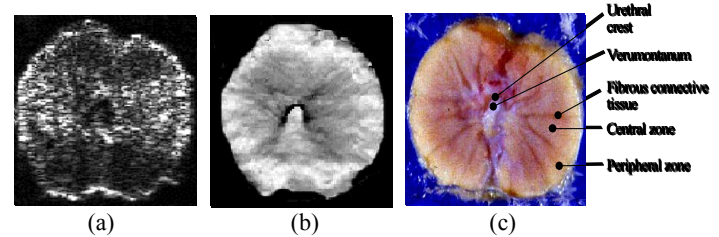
a) Sonogram, b) Elastogram and c) Pathology of a canine prostate in vitro. Note that, in this case, black and white denote highest and lowest strains, respectively.
